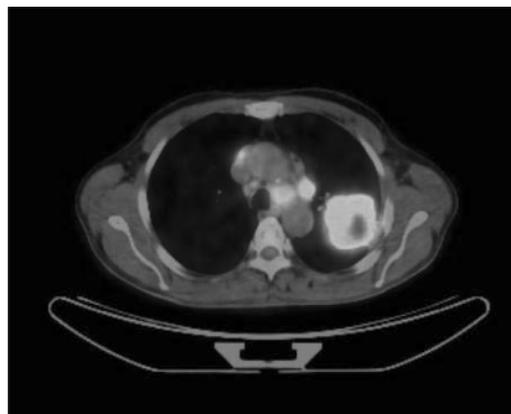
PET CT Fused image
